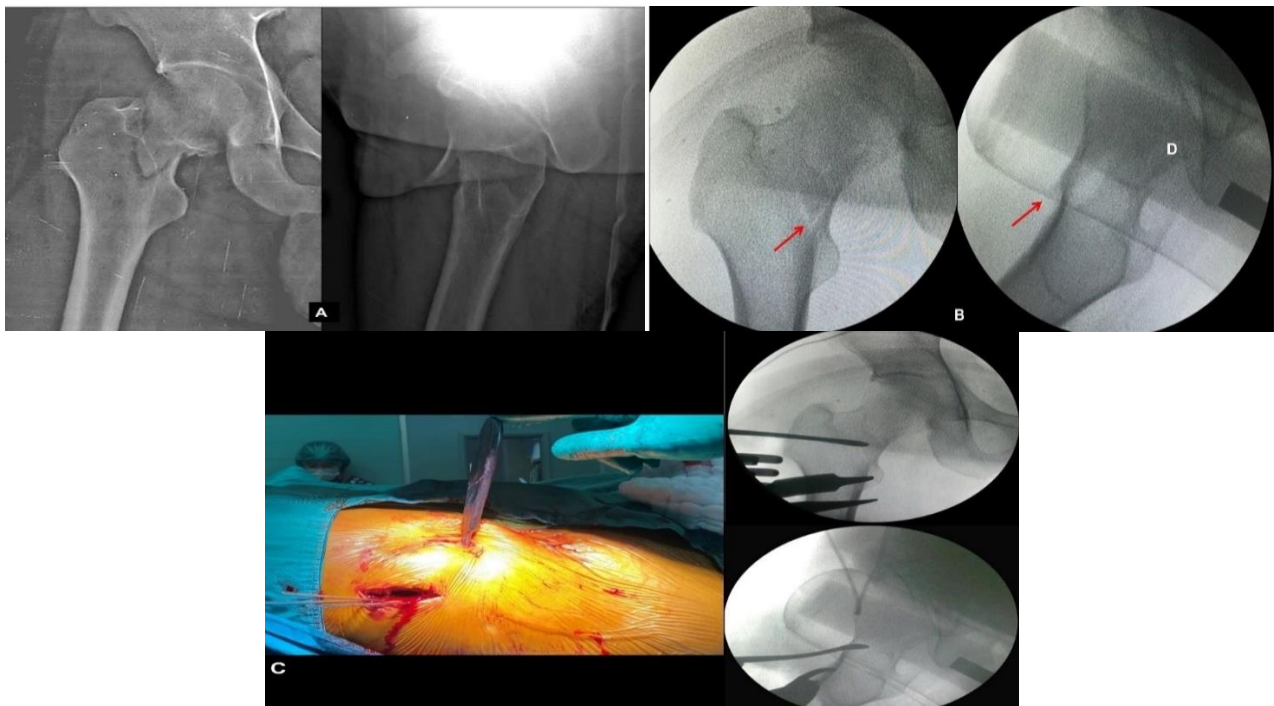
Anteroposterior (AP) and lateral radiographs showing a femoral neck fracture with anterior displacement (A), intraoperative AP and lateral radiographs showing anterior displacement of the femoral neck (arrow) (B), AP and lateral radiographs after fixation with sliding hip screw and anti-rotation screw (C), percutaneous reduction with blunt periosteal elevator with perfect reduction (D)
